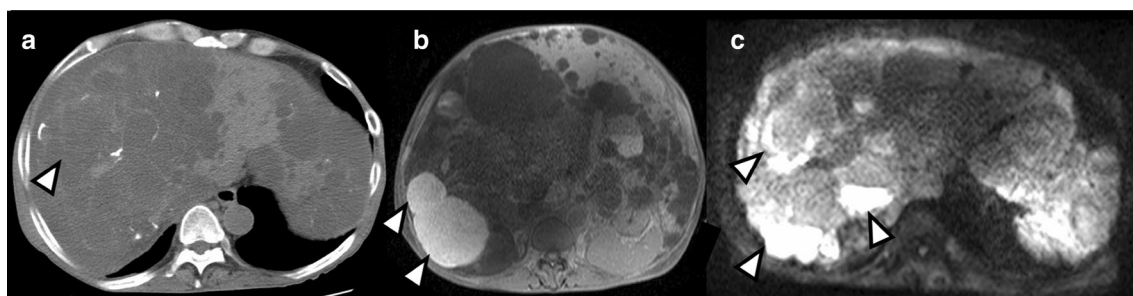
Abdominal contrast-enhanced CT and MRI (on the second admission): multiple cysts of various sizes were observed in the enlargements of the liver and both kidneys. Almost the entire liver was converted into cysts, although the parenchyma remained in some areas (Gigot Classification Type III). Multiple complicated and non-complicated cysts including the cyst represented by red arrow were
